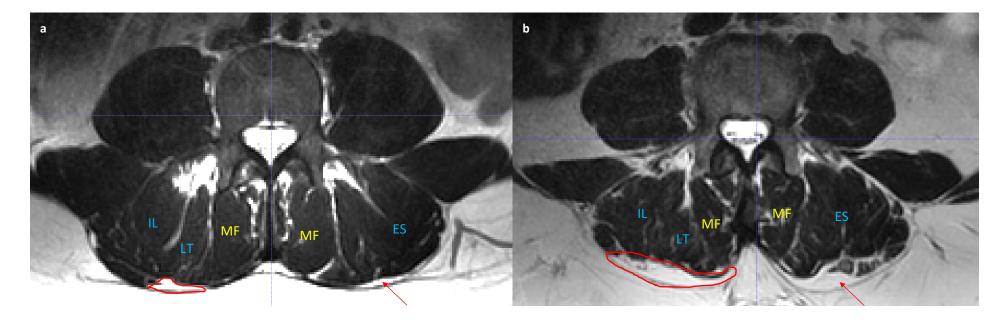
Axial MRI images at the superior endplate L4 of a younger (a) and older (b) participant. The arrows and outlined areas identify the region of fatty tissue under the fascial plane and between the longissimus thoracis (LT) and iliocostalis lumborum (IL).
